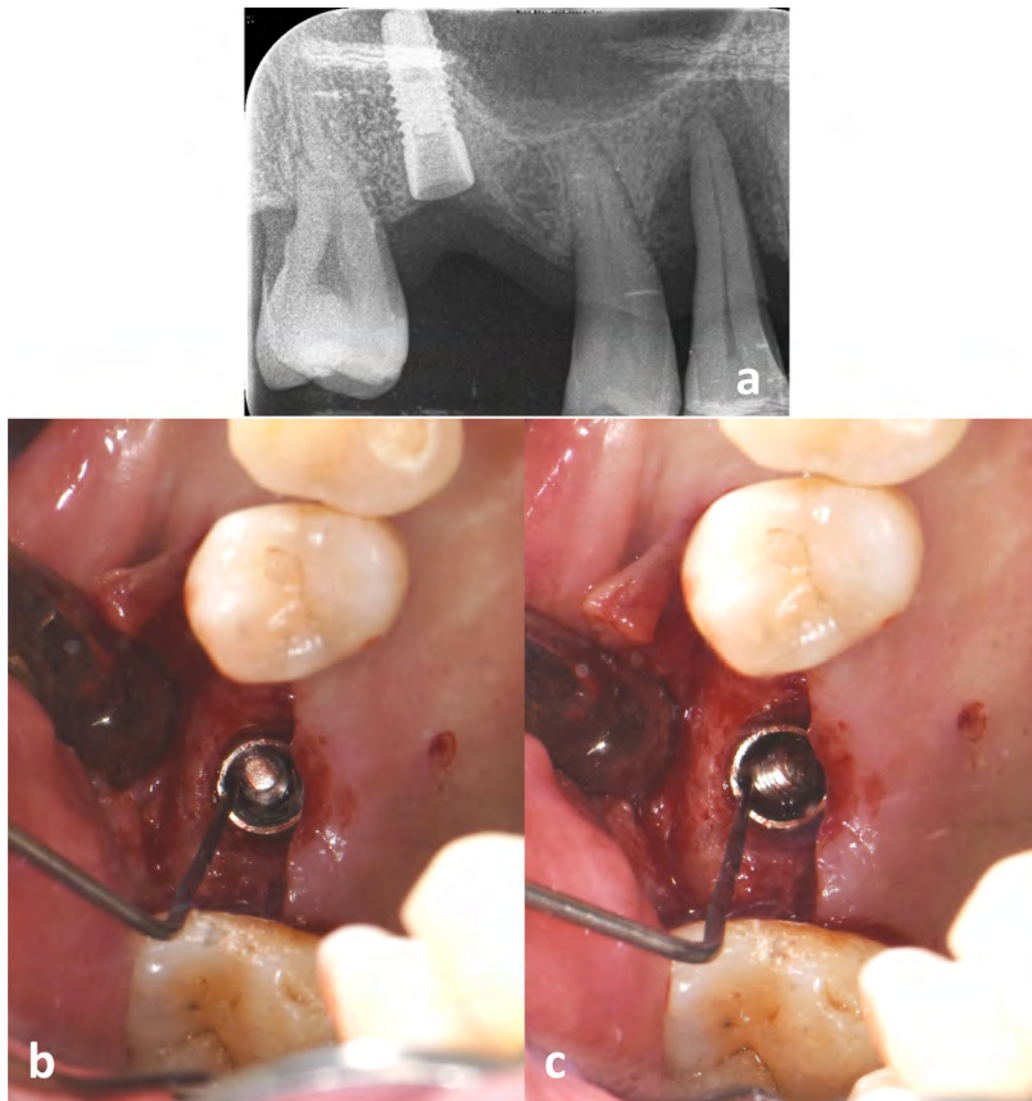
(a) Fractured screw observed on periapical radiograph. (b) The fragment's end point is found using an endodontic explorer. (c) The fragment is removed through counter-clockwise rotation.
